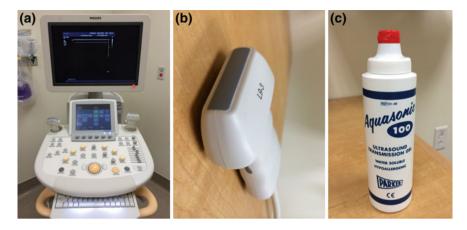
Abdominal CT images. a Portable ultrasound scanner. b Ultrasound scanning probe (source and receiver), and c conducting gel to facilitate sound wave transmission from the probe into the body
